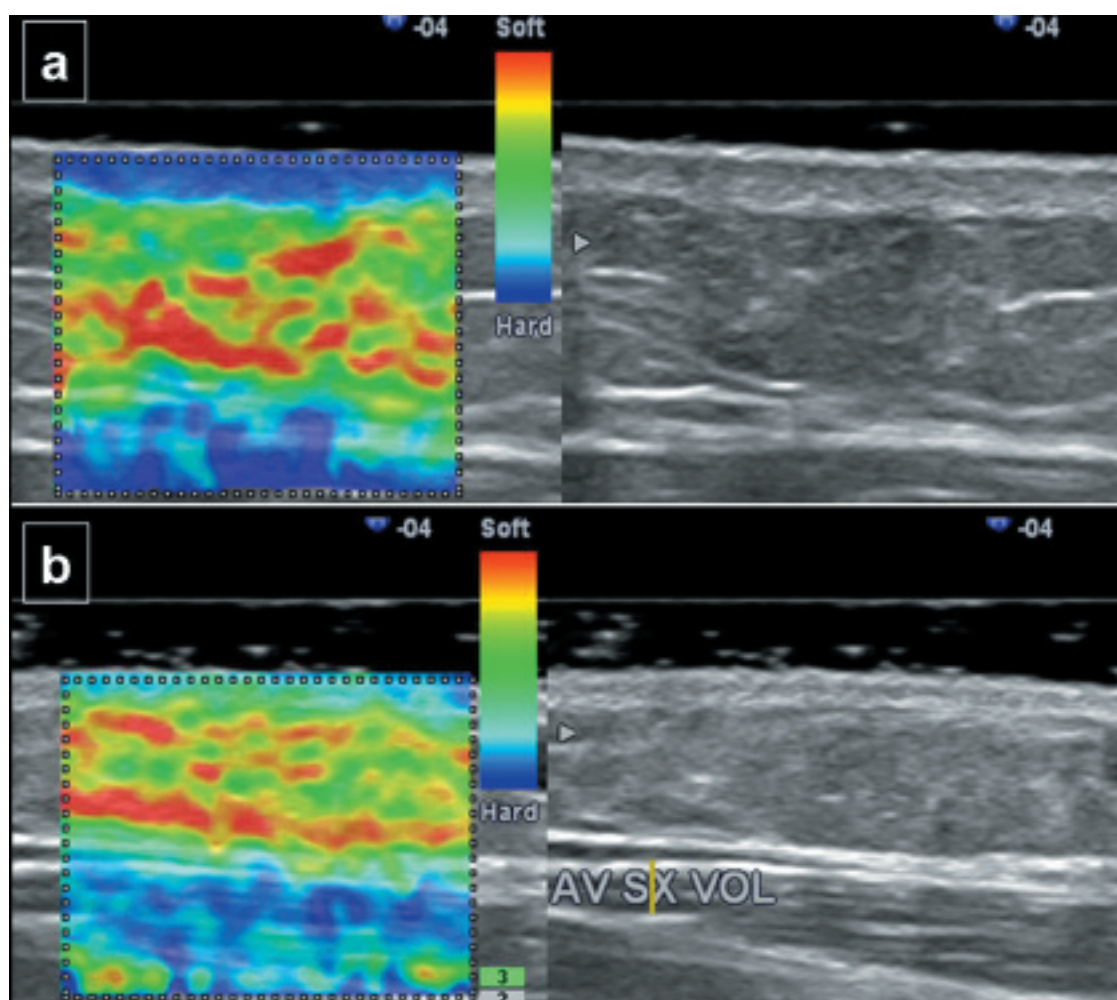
Ultrasound elastography of the volar aspect of the middle forearm in a patient with SSc (a) and in a healthy subject (b). On the left side of (a), a homogeneous blue area with regular margins appears to perfectly correspond to the dermis visualized in B-mode ultrasound (right side). The left side of (b) shows a predominance of green and sporadic areas of pale blue, corresponding to the dermis visualized in B-mode ultrasound (right side).
